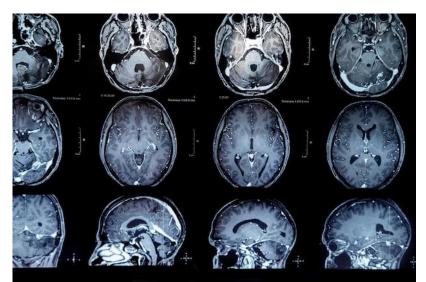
Magnetic resonance imaging MRI showing radiological findings of the brain in a patient with COVID-19 and anosmia pictures
